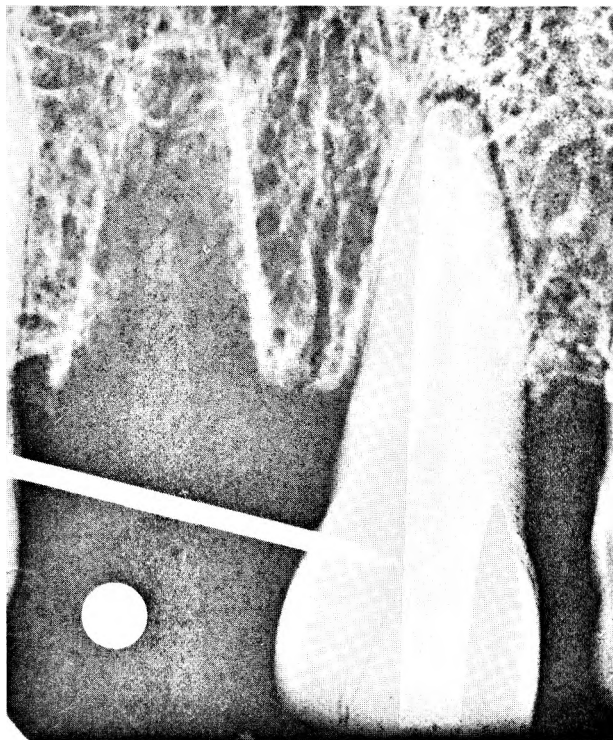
An upper central incisor with metal pointer placed at the cemento-enamel junction. A 2 mm steel sphere is seen. In this case it is attached to the radiographic film.
